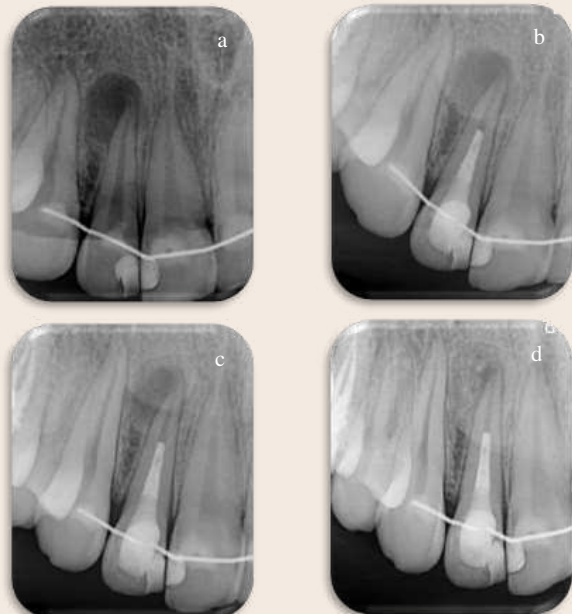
a.The initial radiography b.Post-treatment c.6-month follow-up d.12-month follow-up radiographs of tooth #12
